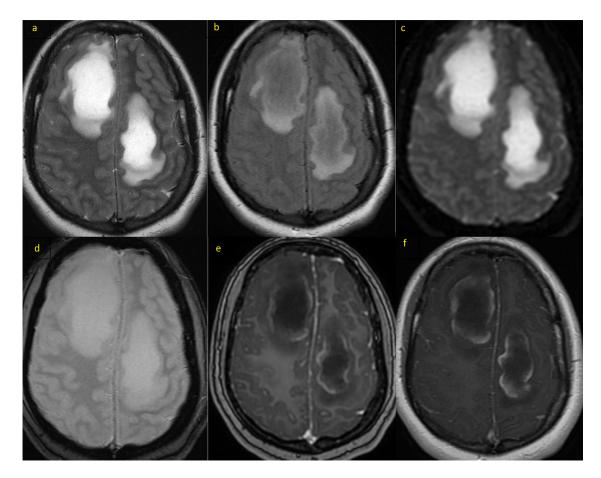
Axial Brain MRI before treatment: Large bilateral frontals lesions hyperintense on T2 (A), FLAIR (B) et DWI (C), without any loss of signal on T2\* (D). It enhances with a discontinuous ring pattern in gradient T1 MPRAGE (E) and T1 FSE (F)
